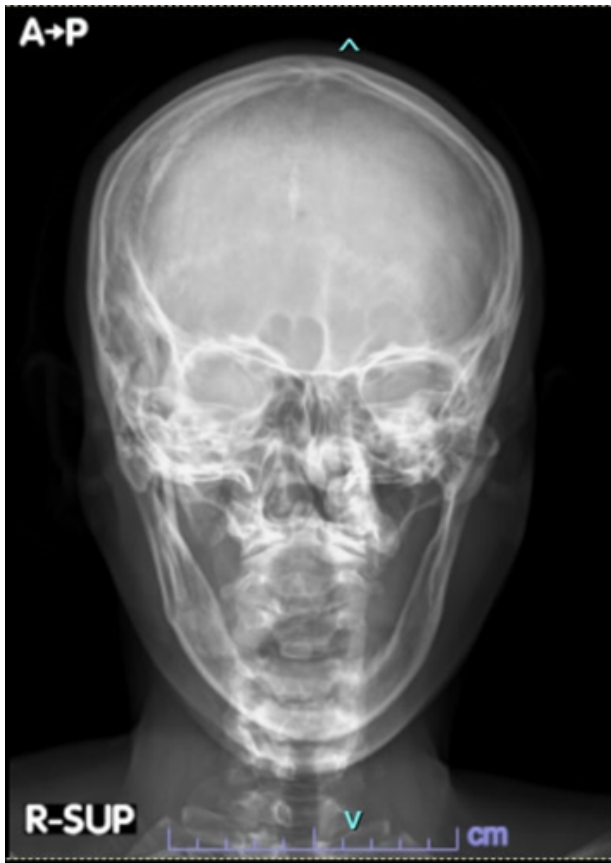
Anteroposterior skull x-ray showing loss of all teeth.
